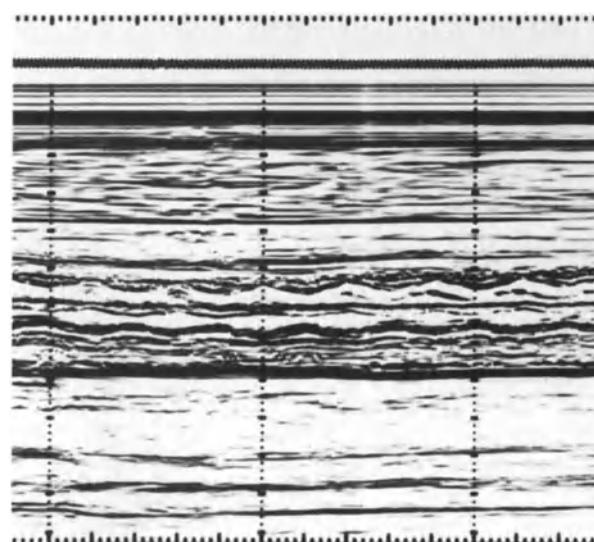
Fetal M-Mode echocardiogram. The contractility of two equal sized ventricular free walls can be seen on either side of the interventricular septum. A regular fetal heart rate of 150/min can be calculated from the 1-second time markers.
